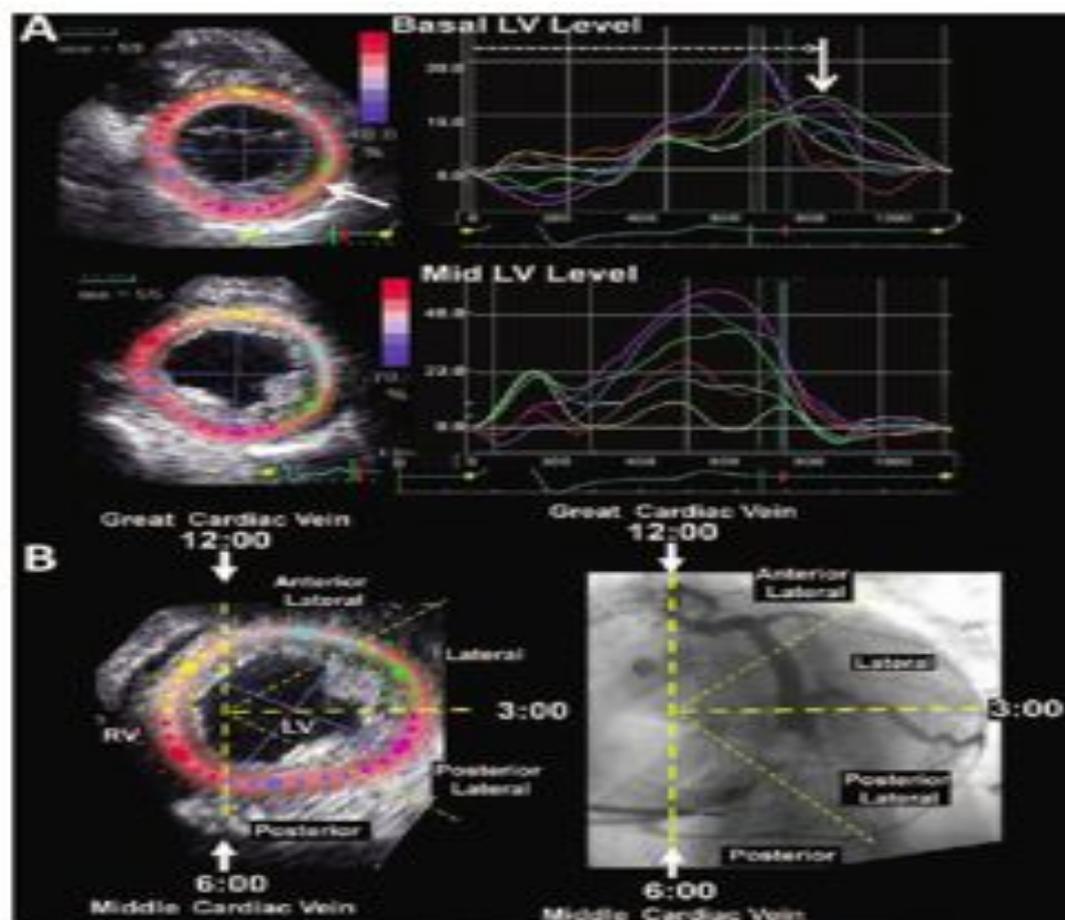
A, Top: Short-axis echocardiographic speckle tracking images at basal and mid-left ventricular (LV) levels with 6 color-coded time-strain curves per image to the left. Site of latest mechanical activation (arrows right top) was determined to be basal lateral (left top). B, Bottom: Segmentation of mid-LV short-axis view on left for coregistration with coronary venous anatomy from the left anterior oblique projection on right. A clock-face analogy with the great cardiac vein at 12.00 and the middle cardiac vein at 6.00. The LV free wall was divided into 4 segments according to coronary venous anatomy (with corresponding speckle tracking software labels listed first): Anterior, anterolateral; lateral, lateral; posterior, posterolateral; inferior, posterior. RV indicates right ventricle. Also, LV length was divided into thirds from the right anterior oblique fluoroscopic projection.
